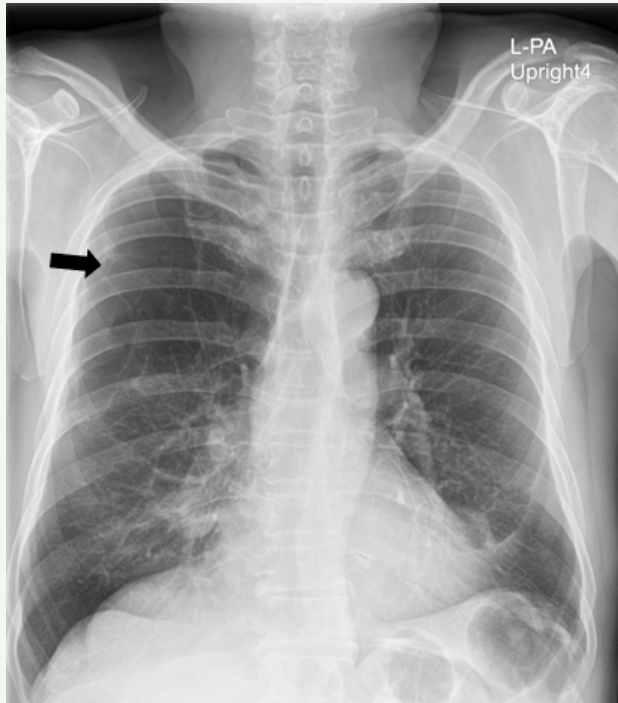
Chest radiograph PA upright showed multiple lung blebs and bullae (black arrow) in the right upper to middle lung field.
